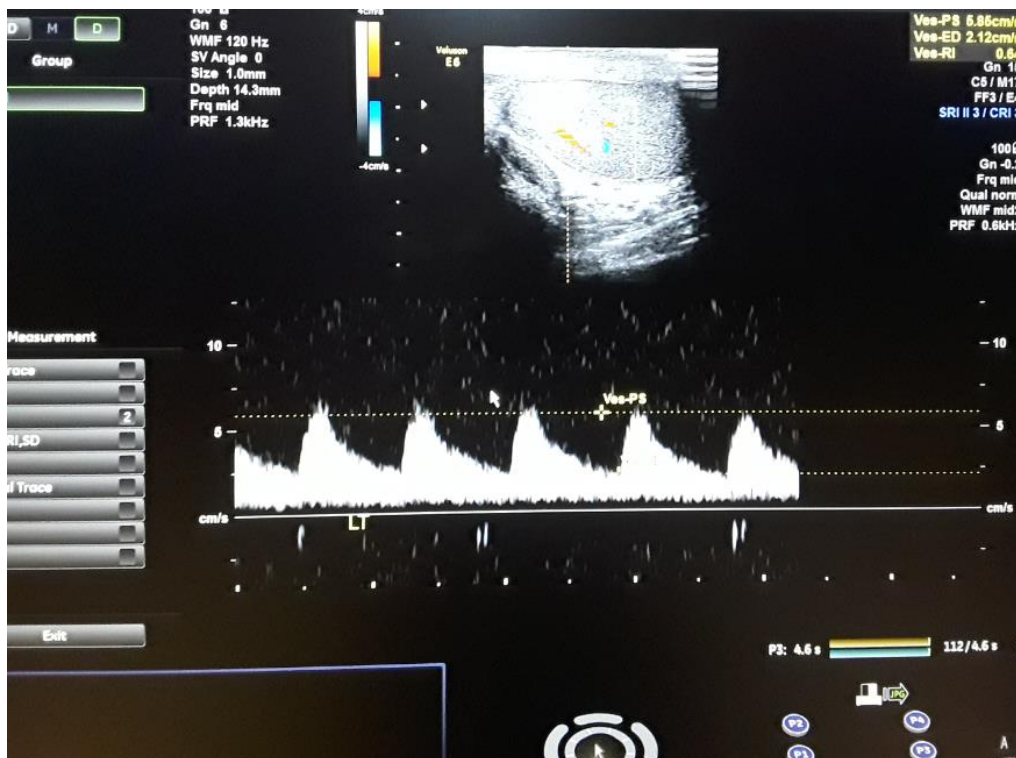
Doppler (RI) study.
